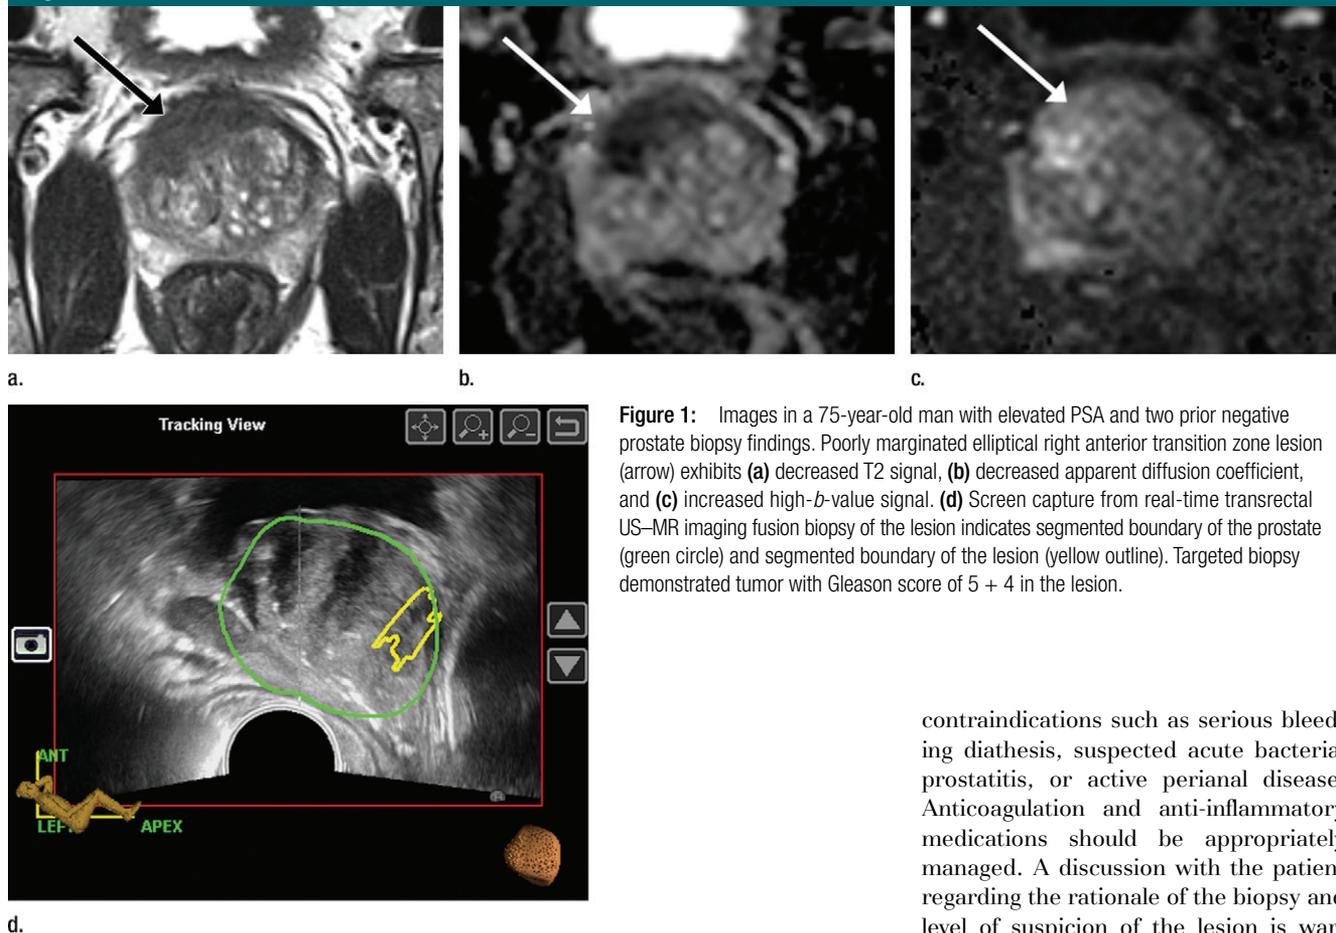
Images in a 75-year-old man with elevated PSA and two prior negative prostate biopsy findings. Poorly marginated elliptical right anterior transition zone lesion (arrow) exhibits (a) decreased T2 signal, (b) decreased apparent diffusion coefficient, and (c) increased high-*b*-value signal. (d) Screen capture from real-time transrectal US–MR imaging fusion biopsy of the lesion indicates segmented boundary of the prostate (green circle) and segmented boundary of the lesion (yellow outline). Targeted biopsy demonstrated tumor with Gleason score of 5 + 4 in the lesion.
